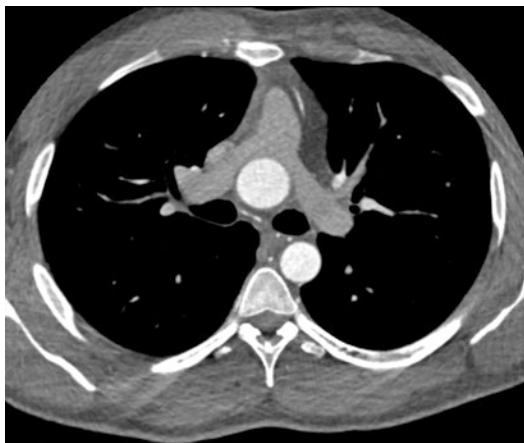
Lecompte maneuver performed during arterial switch procedures. CT demonstrating the pulmonary artery draped over the ascending aorta. Proximal obstruction of the branch PAs may occur
